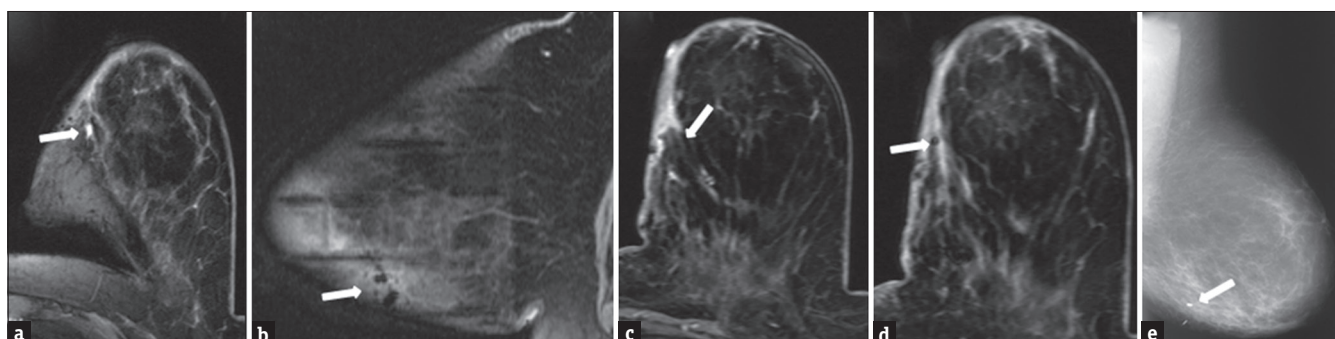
55-year-old with left bloody nipple discharge status postductal excision which revealed a 1 cm noninvasive papillary carcinoma with positive margins. Postoperative MRI demonstrated a suspicious 5 mm focus of enhancement close to the excision site which needed to be included in the surgical re-excision. Due to small size of lesion, and lack of correlate on mammogram and ultrasound, an magnetic resonance imaging guided clip placement was performed. (a) Postcontrast axial sequence from the postoperative diagnostic breast magnetic resonance imaging demonstrating a suspicious 5 mm focus of enhancement (arrow) close to the excision site in the medial inferior left breast. (b) Sagittal image from the precontrast sequence demonstrates the grid to be well positioned with the postsurgical region (arrow) included in the field of view and within the grid. (c) Axial postcontrast sequence with a medial grid in place demonstrates the enhancing mass (arrow) abutting the skin to be well positioned within the grid. The mass appears closer to the skin compared to the diagnostic magnetic resonance imaging due to compression from the medial grid. (d) Postprocedure magnetic resonance imaging demonstrating the clip (arrow) to be well positioned within the enhancing mass. (e) The clip was subsequently localized with a radioactive seed using a digital technique. Postlocalization mammogram demonstrating the seed to be in close proximity to the biopsy clip.
